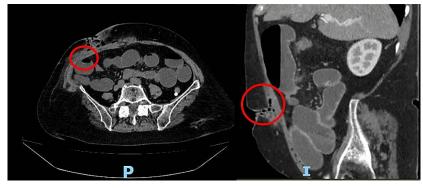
CT scan in coronal and sagittal planes
